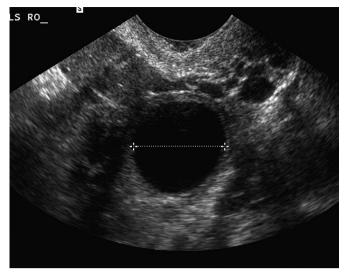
Transvaginal ultrasound image of simple ovarian cyst. Note the thin, smooth capsule with no evidence of internal echoes.
